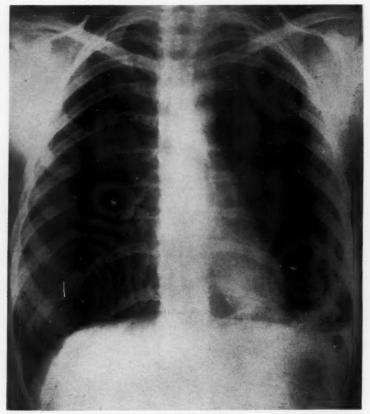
Chest x-ray on third day after admission, showing regressive changes of pulmonary infarction.
